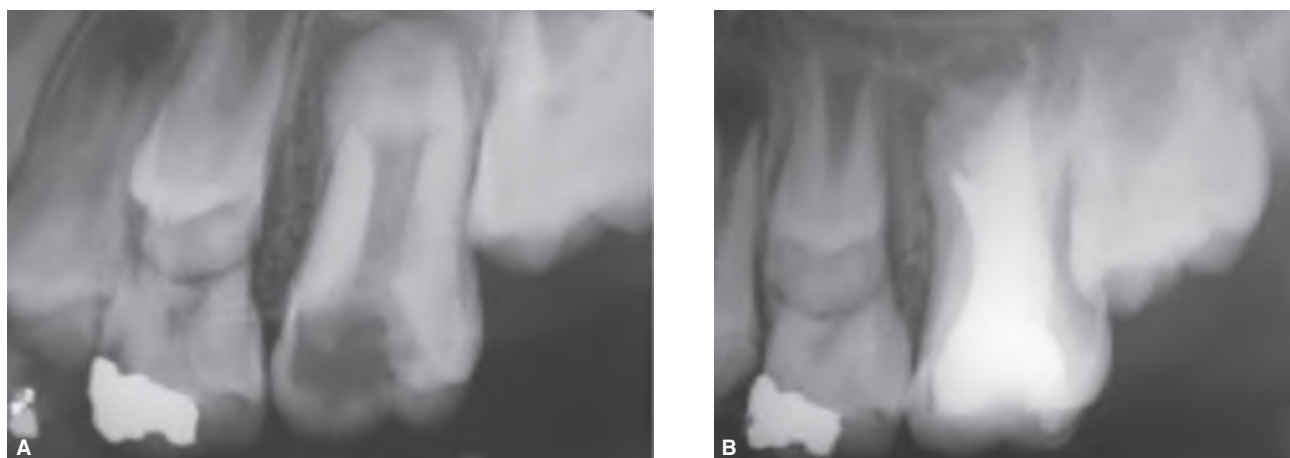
Taurodontism (hyper-type) in a symptomatic maxillary first molar of a 10-year-old male. A buccal apical swelling was detected. A. Preoperative radiograph. B. Postoperative radiograph following obturation with thermoplasticized gutta-percha and sealer. The patient is asymptomatic. (Courtesy of Dr. Lourdes Lanzagorta Rebollo, Instituto de Endo-Meta-Endodoncia, México.)
